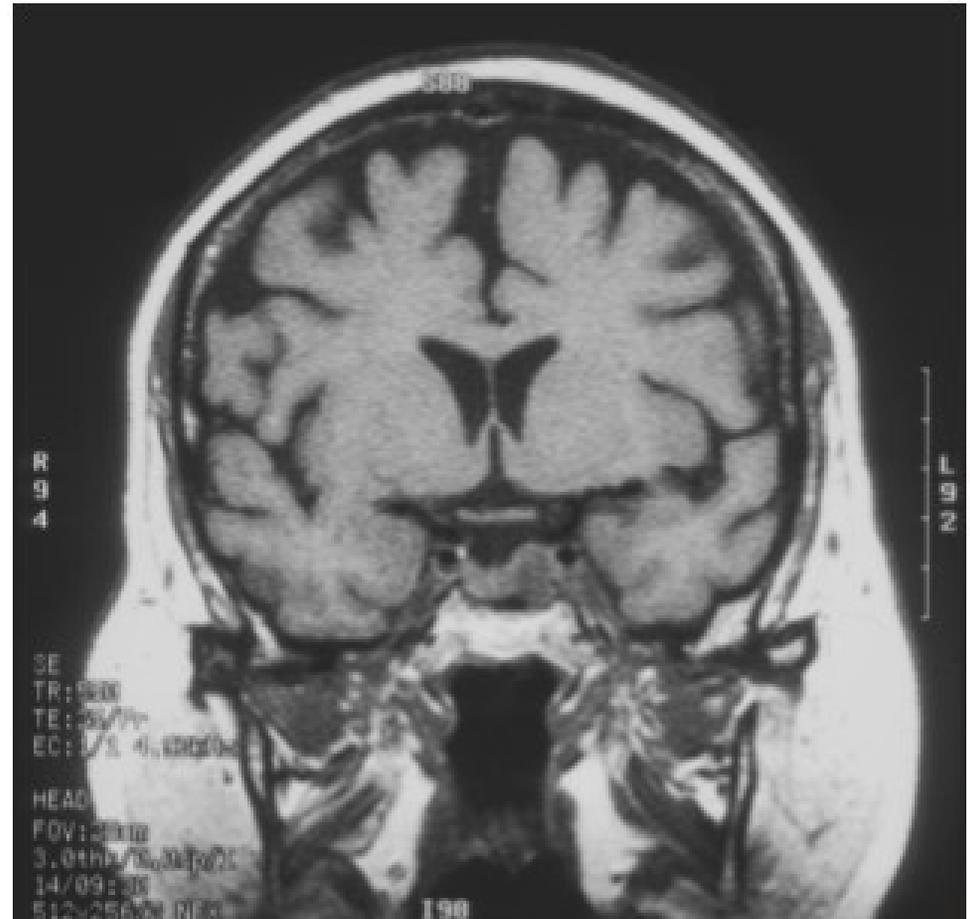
Magnetic resonance image showing brain atrophy in a 32-year-old woman with Cushing's disease.
